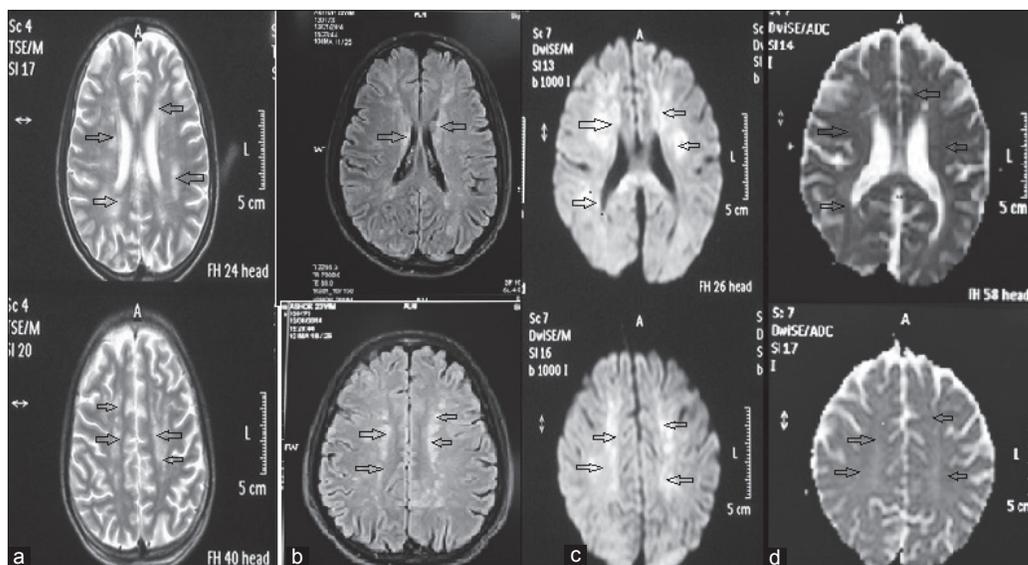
Initial magnetic resonance imaging (day 2). (a) T2-weighted images showing multiple small focal areas of hyperintensities in the deep and periventricular white matter of bilateral cerebral and cerebellar hemispheres, in bilateral corona radiata and basal ganglia. (b) Fluid-attenuated inversion recovery sequence showing hyperintensities in above region. (c) Diffusion-weighted imaging images showing restricted diffusion in the above region. (d) Apparent diffusion coefficient map showing mild reversal in the above region
